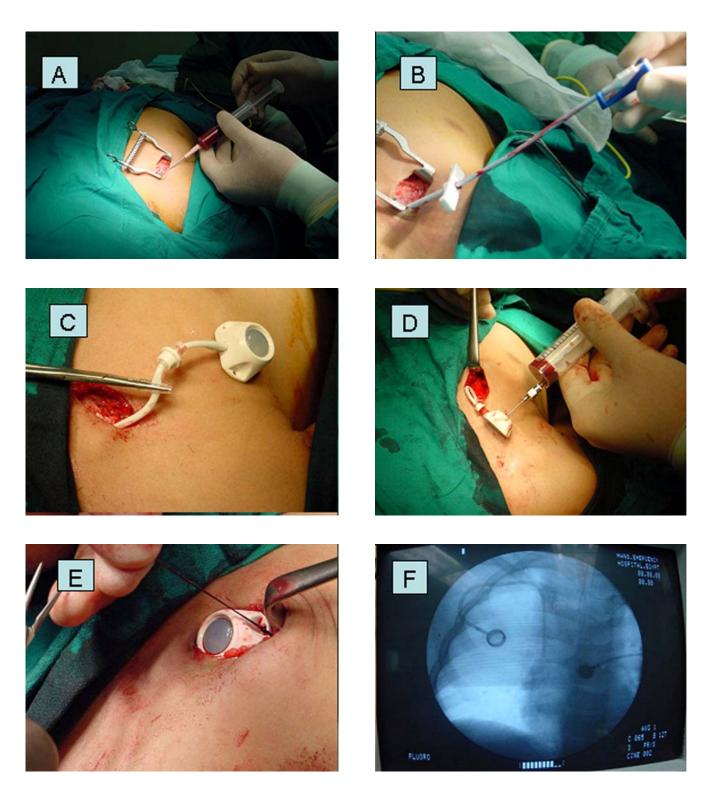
Technique of subcutaneous port system implantation. A: Subclavian vein puncture, B: Subclavian vein cannulation, C: Complete Port system connected, D: Port final testing before implantation, E: Fixing & implanting the port, F: Postoperative Chest x-ray.
